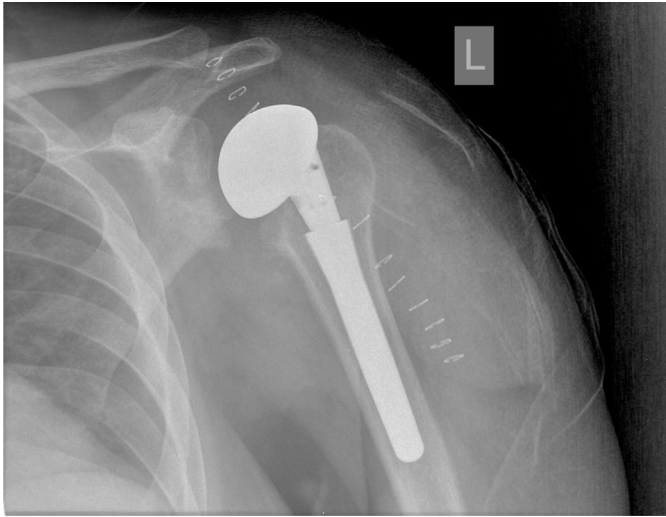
Anteroposterior view of the shoulder. The postoperative radiographs of the revision show a better match between the stem of the prosthesis and the humeral canal.
